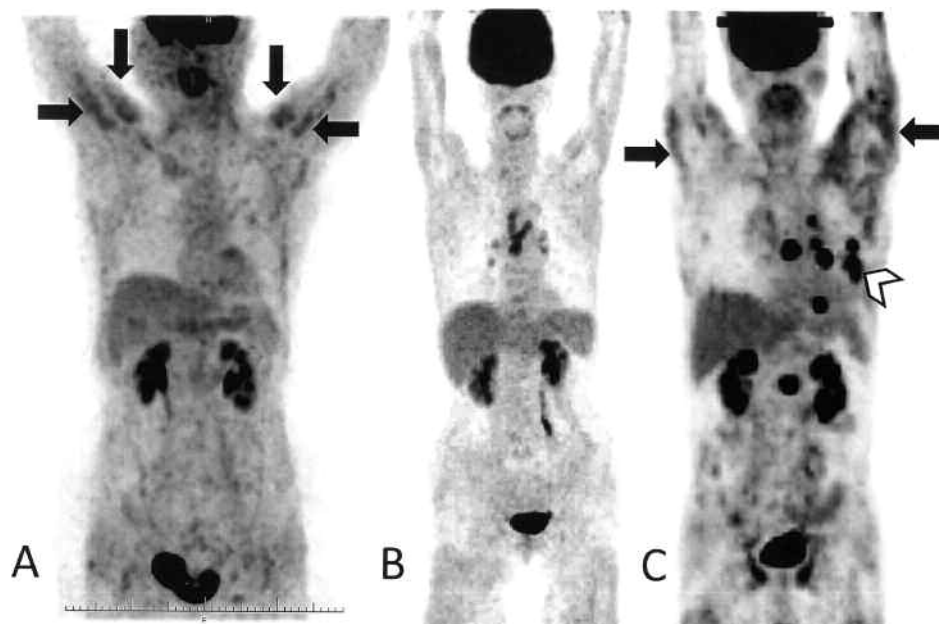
F-18 fluorodeoxyglucose (FDG) positron emission tomography in patients with polymyositis/dermatomyositis (PM/DM). (A) Patient with FDG uptake in muscles (Case 17). (B) Patient without FDG uptake in muscles (Case 7). (C) Patient with DM associated with malignancy (Case 24). Arrows indicate FDG accumulation, arrowhead indicates lung cancer.
